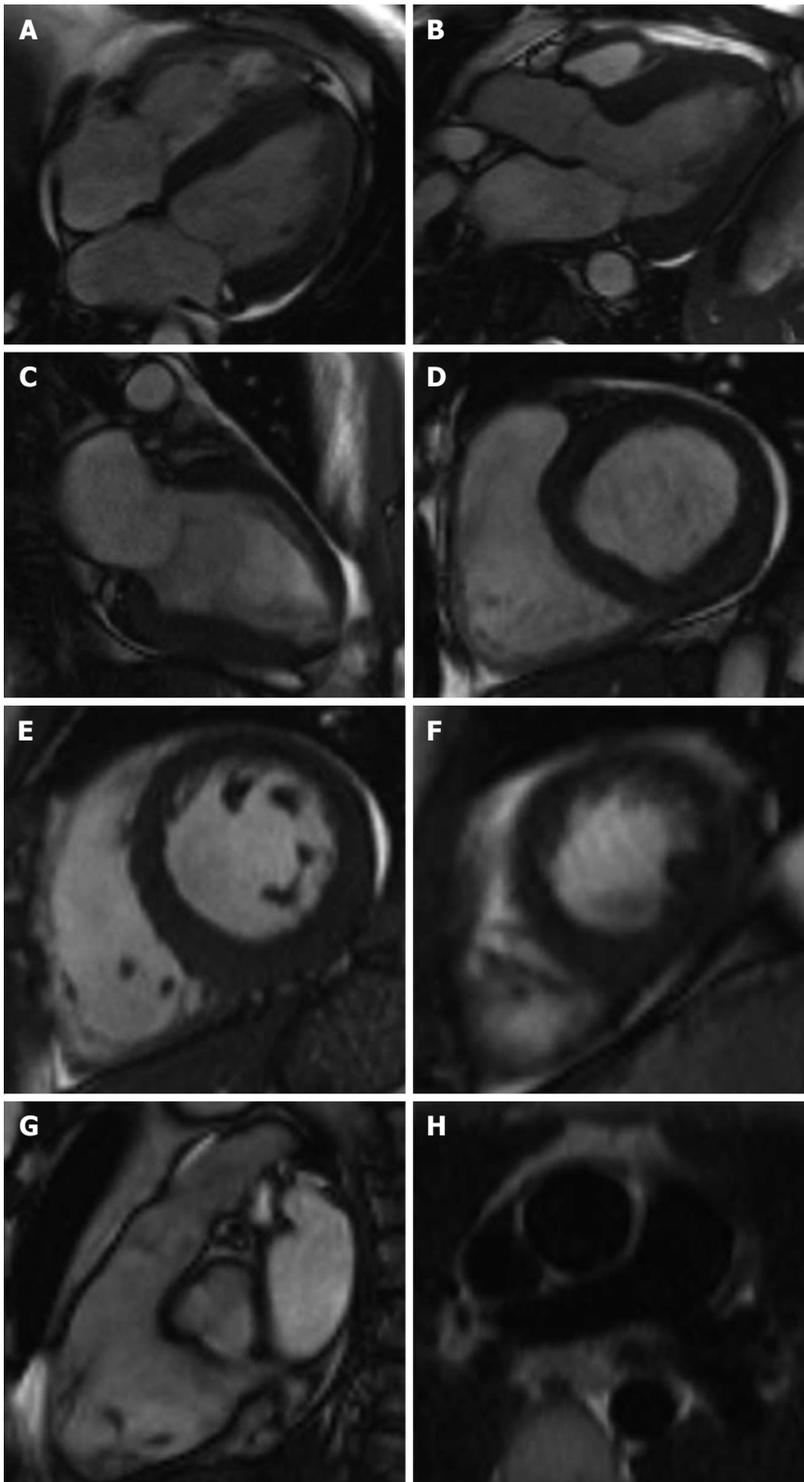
Standard imaging technique showing cine magnetic resonance imaging long axis views (A-C) and followed by short axis (D-F) and RVOT (G). Half-Fourier acquisition single-shot turbo spin-echo image shows the main, left and right pulmonary arteries (H).
